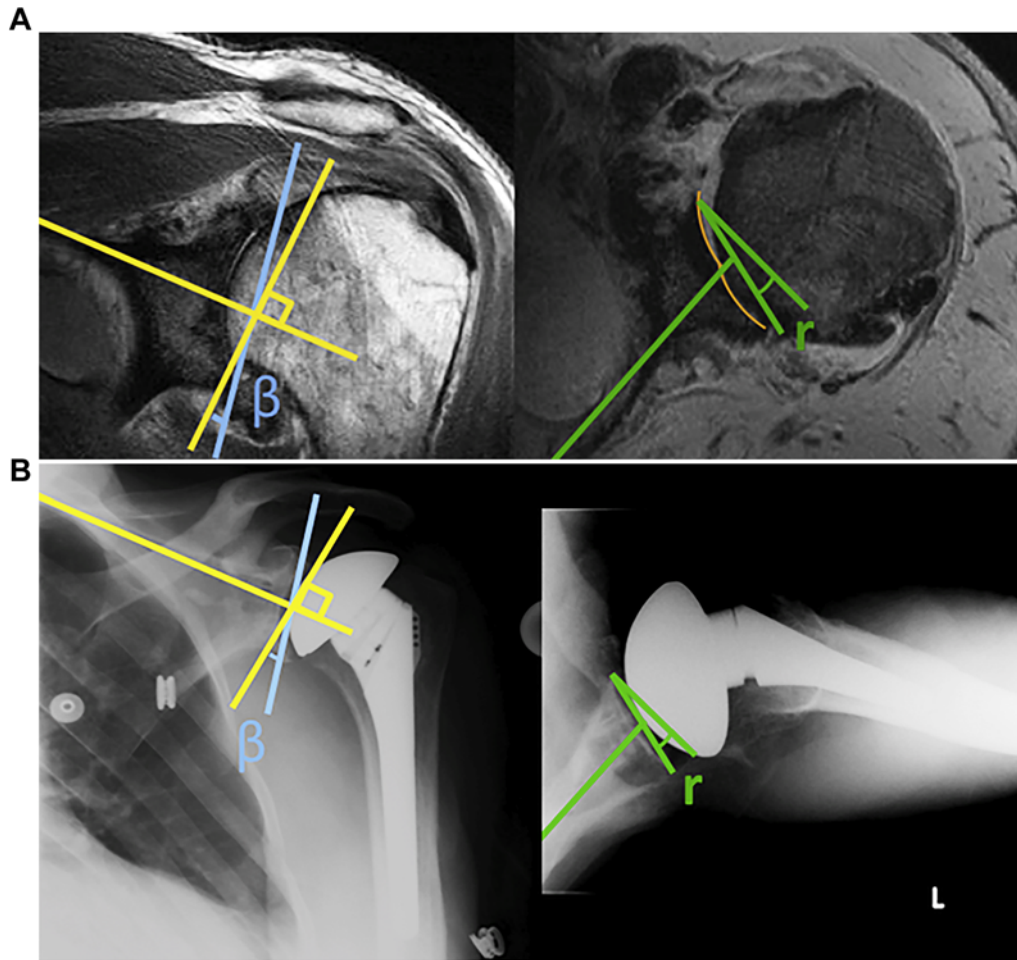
(A) Preoperative magnetic resonance image and (B) postoperative radiographs demonstrating the minimal noncorrective reaming technique. The anteroposterior view shows persistent glenoid inclination (β) and the axillary view demonstrates remaining retroversion (r).
